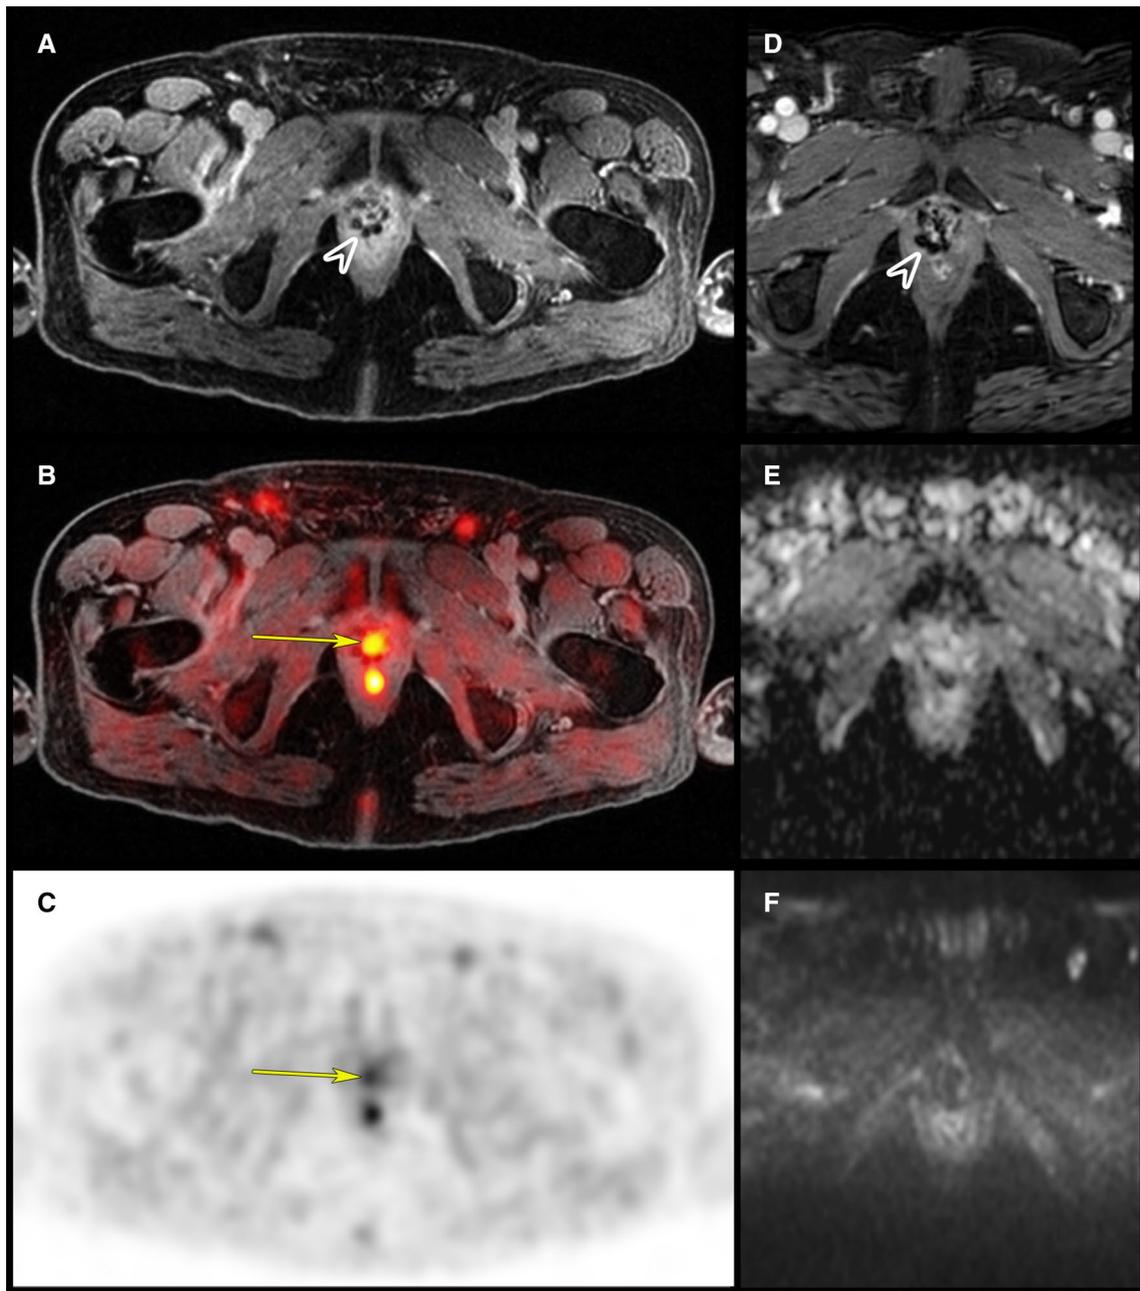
FCH PET/MRI images showing a local recurrence with positive FCH (yellow arrows) and negative mpMRI findings in a 66-year-old man with a pT2a pN1 R0 Gleason 4+5 disease in biochemical recurrence (PSA 1.1 ng/ml) after radical prostatectomy. a Dixon water sequence, b FCH uptake on fused PET/MR image, c native
